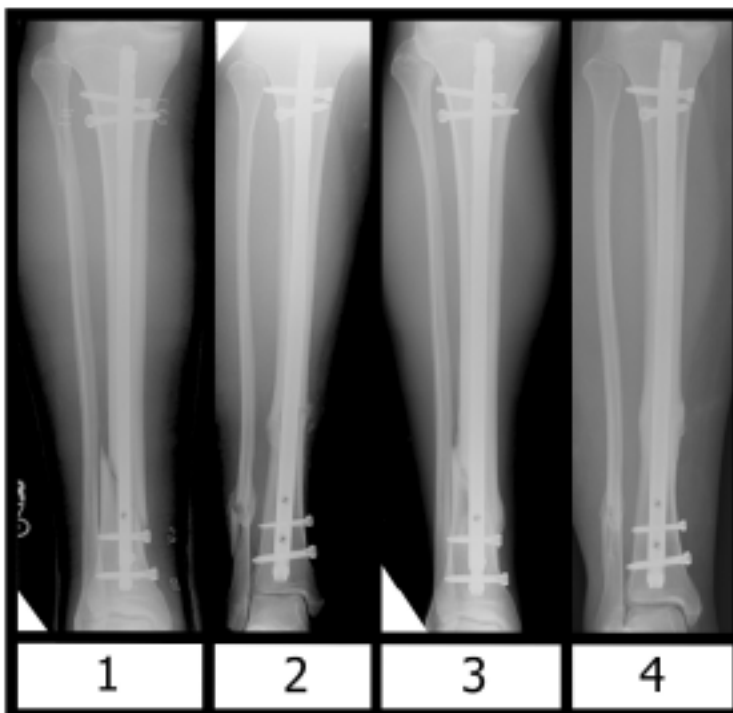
Radiographic grading of fracture healing was independently graded based on a 0 to 4 scale in a blinded fashion by a musculoskeletal radiologist.
